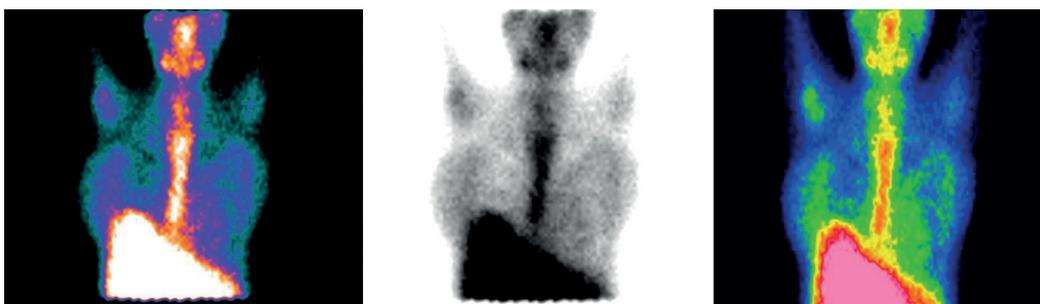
Cardiac scintigraphy obtained in the anterior view of the chest (72 hours after administration of the radiopharmaceutical), showing gallium-67 diffuse uptake in the cardiac area graded as mild to moderate.
